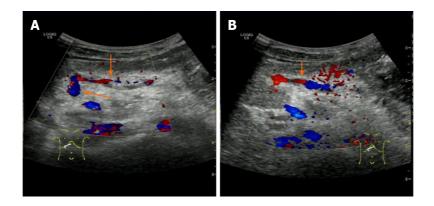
Color Doppler ultrasonography of a 9-year-old boy after recanalized umbilical vein as a conduit for Rex shunt (gastric coronary vein-umbilical vein shunt). A: Color Doppler flow imaging (CDFI)showed intermittent blood flow signal in the bypass vessel (gastric coronary vein) 7 d after operation; B: CDFI showed that the bypass vessel was well filled with blood flow signals after clinical anticoagulation treatment for 3 mo. Long arrow indicates umbilical vein and short arrow indicates gastric coronary vein.
